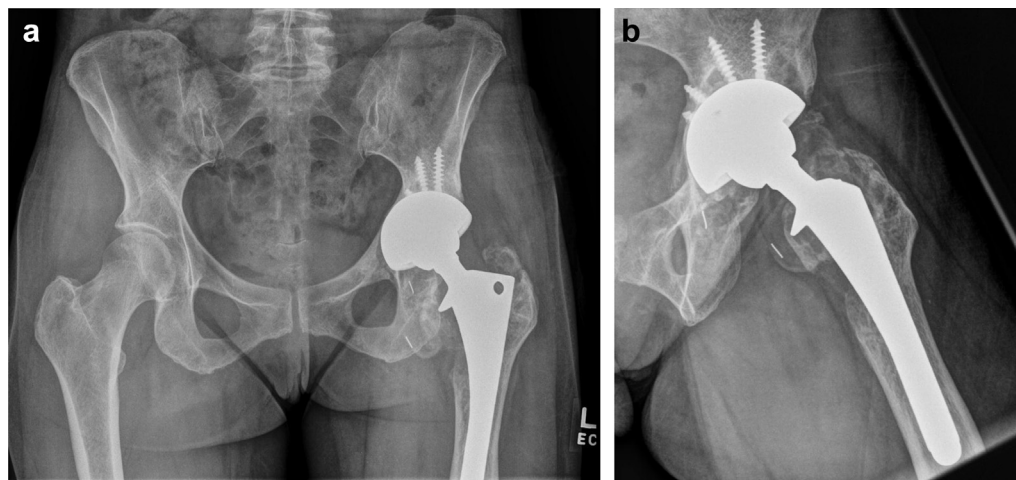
Anteroposterior (a) and frog-leg lateral (b) radiographs of the left hip revision arthroplasty 20 months postoperatively showing progressive healing of the bone graft and incorporation of the ingrowth acetabular component.
